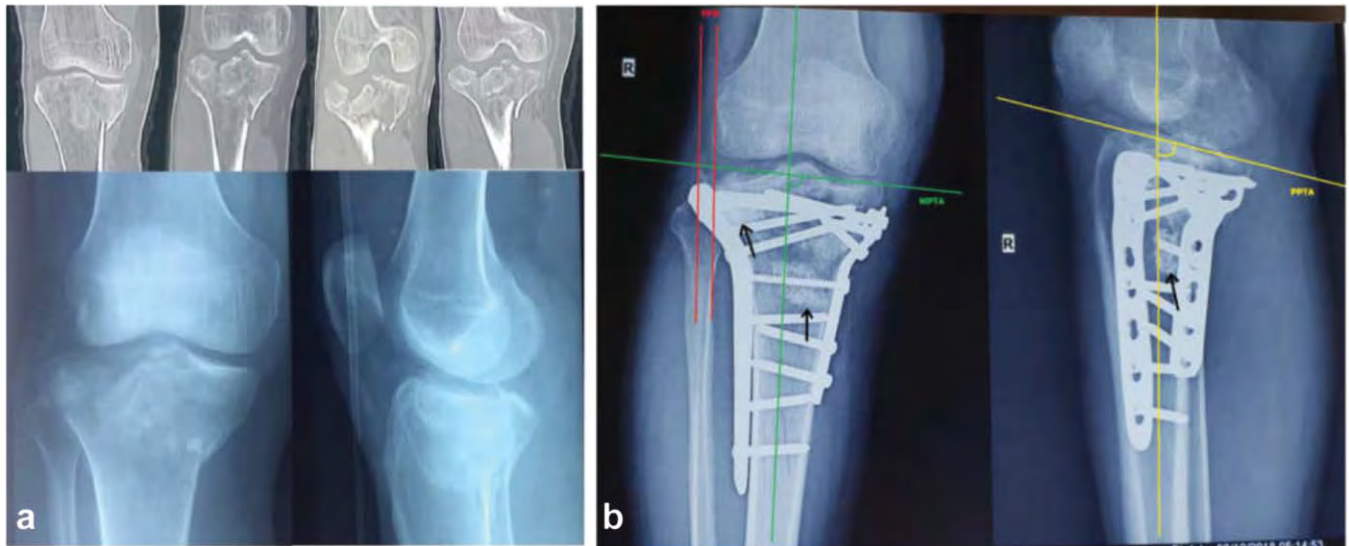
(Case 1): A 40 year old patient with complex tibial plateau fracture. (a) Pre-operative radiograph showing severe comminution of the lateral articular surface. (b) Six months post-operative AP and lateral X-ray with coloured markings for medial proximal tibial angle (green), tibial plateau widening (red) and posterior proximal tibial angle (yellow). Black arrows indicating the structural void filler support with synthetic bone graft substitute.
